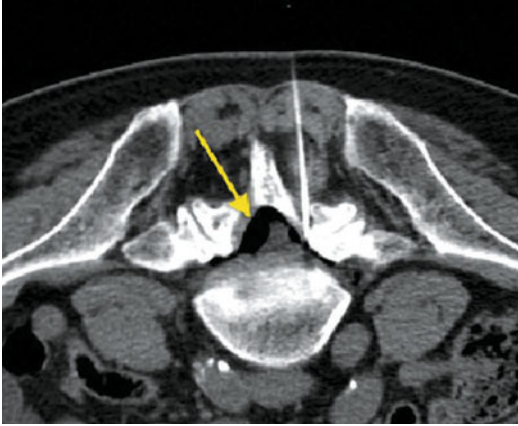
CT showing a spinal needle being inserted through the interlaminar space. Diffusion of ozone inside the epidural space is also shown (yellow arrow)
